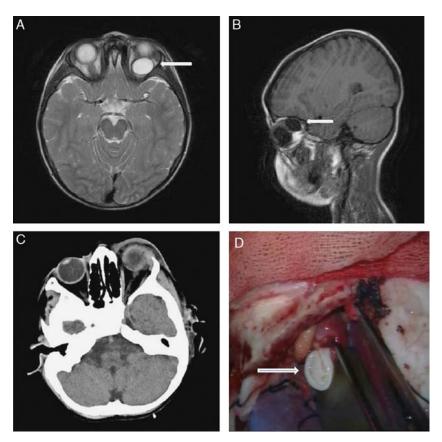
White arrows are showing a retrobulbar homogenous unilocular lesion in posterior-superior of the left orbit which was hyperintense on T2-weighted image (A) and hypointense on T1-weighted image (B). Postoperative cranial computed tomography demonstrated no evidence of the cyst (C). White arrow is showing total removal of the cystic membrane (D).
